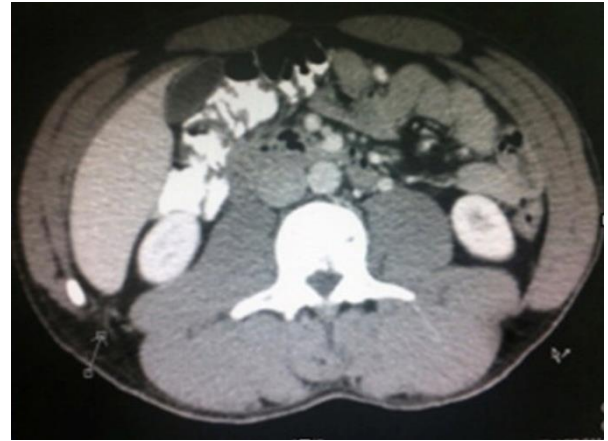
Axial view- CT abdomen the lumbar hernia.
